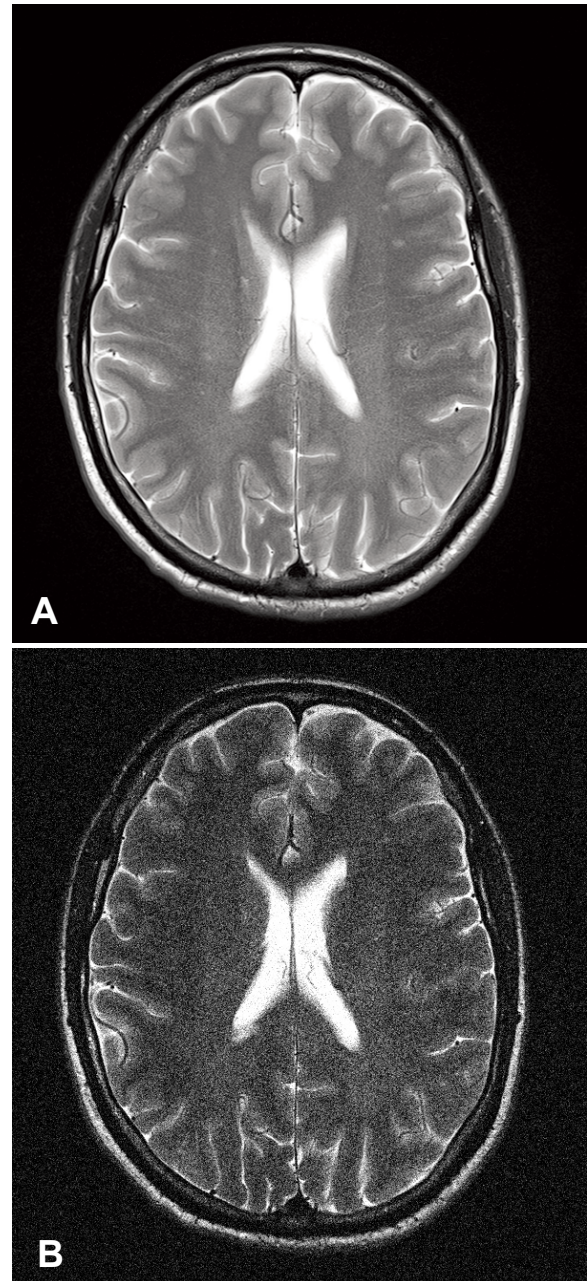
Axial T2-weighted image of the brain. (A) Example of high SNR with no artifact. (B) Example of low SNR. *Courtesy of University of Iowa Carver College of Medicine.*
